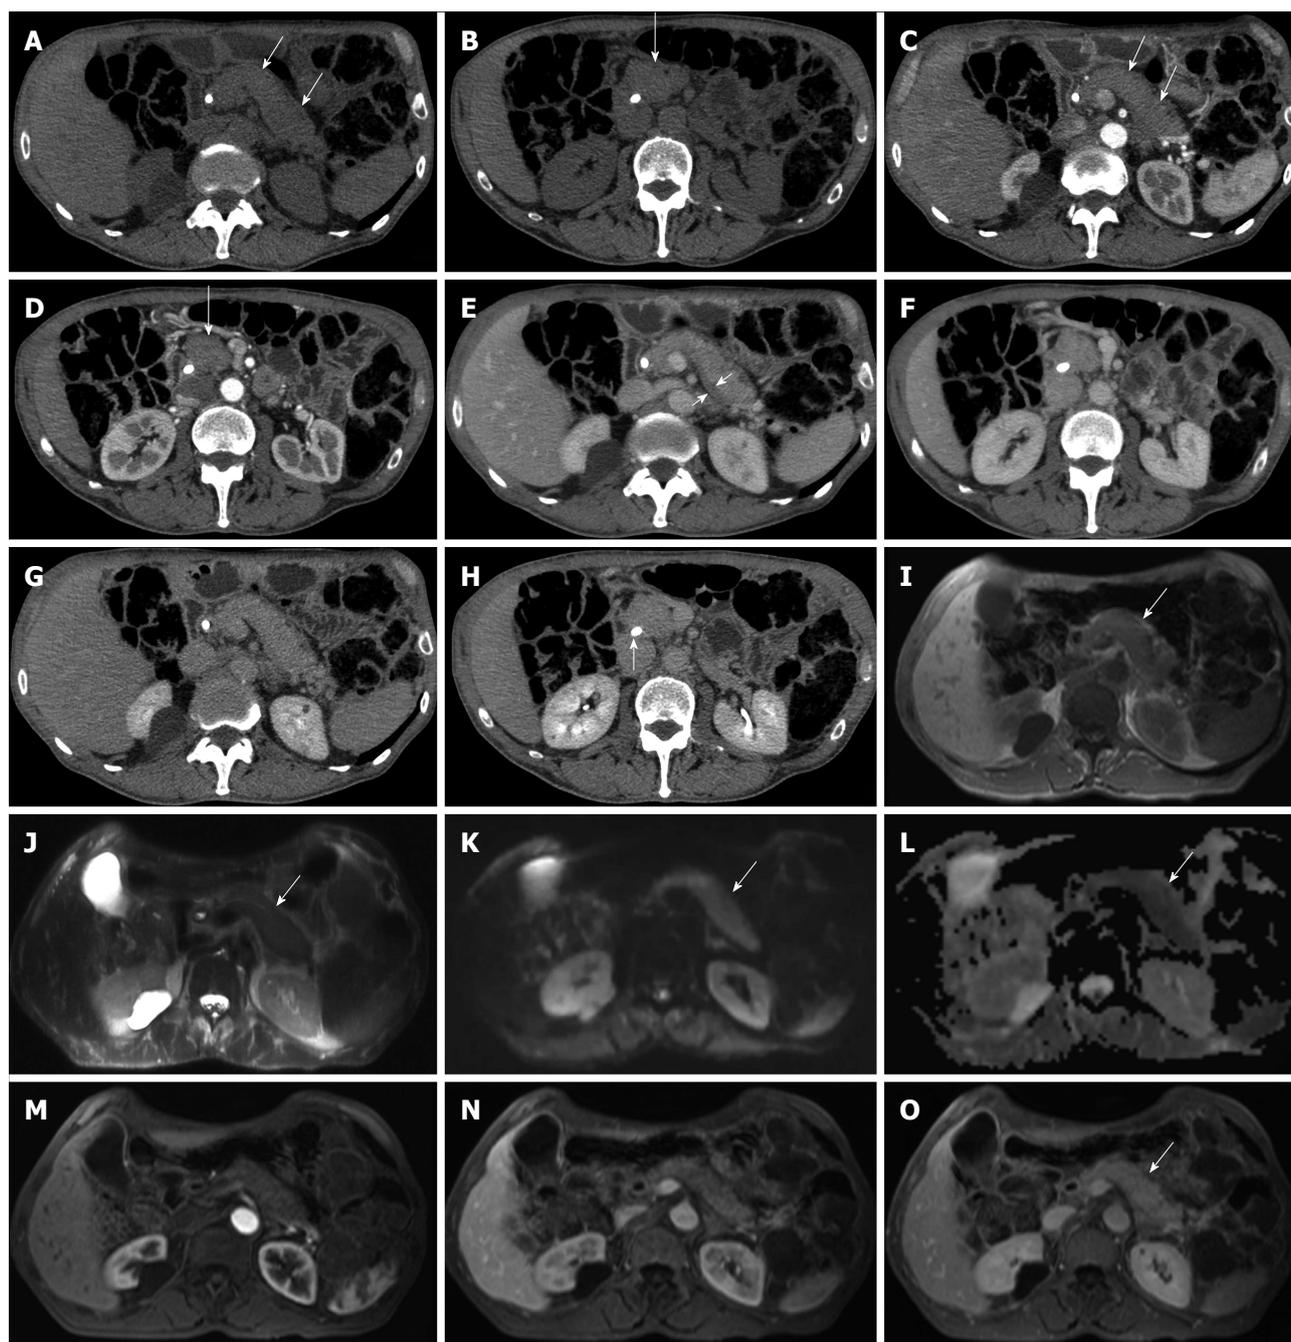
Diffuse-type autoimmune pancreatitis. A-H: Computed tomography: the pancreas appears diffusely enlarged (arrows in A-D) with a hypodense peripancreatic rim, better visible in the venous phase (arrow in E). The lesion shows fair enhancement resulting almost isodense in the delayed phase (G-H). A plastic biliary endoprosthesis is visible in the common bile duct (arrow in H); I-O: Magnetic resonance: the entire organ is slightly hypointense on T1-weighted images (arrow in I) and slightly hyperintense on T2-weighted images (arrow in J), with diffusion coefficient restriction (arrows in K and L) with intermediate-high b values. At dynamic examination the pancreatic lesion presents fair enhancement resulting almost isodense in the delayed phase (arrow in O).
